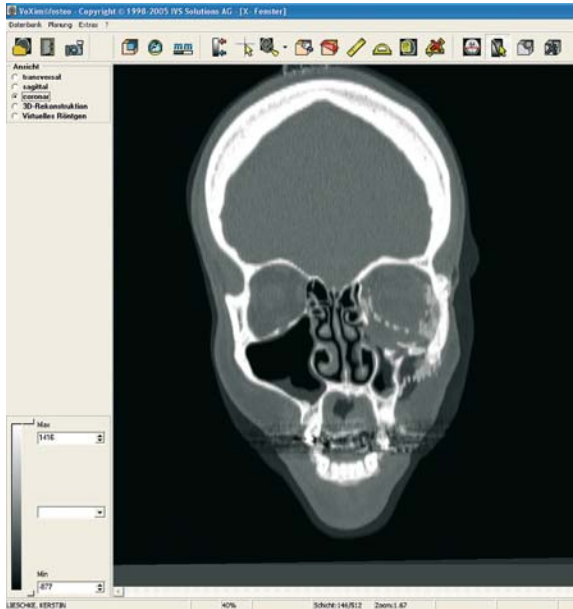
Secondary reconstruction – postoperative evaluation by image fusion. Superimposing the two CT data sets before and after the reconstruction allows better visualization and quantitative evaluation of the postoperative result
